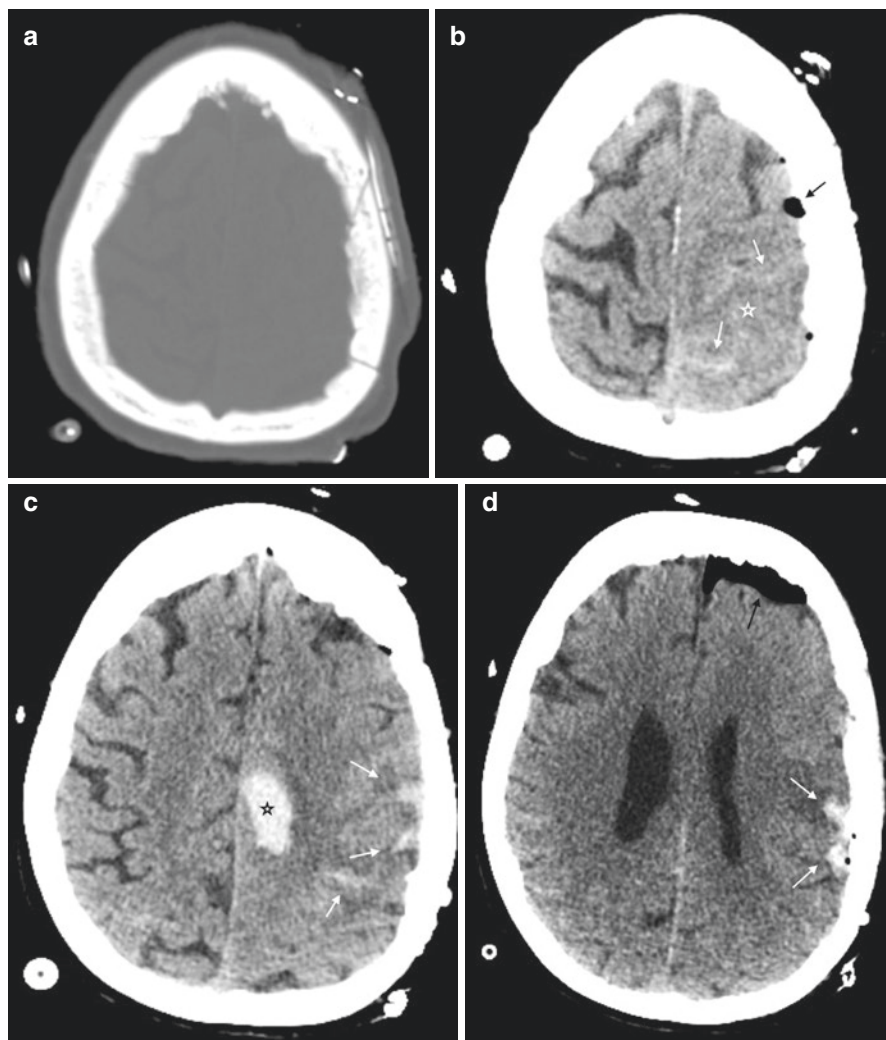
Subarachnoid and intraparenchymal hemorrhages in a 34-years-old woman, after debulking of a meningioma. Axial CT scan (a) shows a frontoparietal craniotomy. Axial CT scans (b–d) show subarachnoid hemorrhage (white arrow) over the left frontal and parietal lobes associated with loss of gray–white differentiation, from combined cytotoxic and vasogenic edema (b) in the left convexity (☆) and pneumocephalus (black arrow). Foci of intraparenchymal hemorrhage (c) along the left gyrus cinguli (☆)
